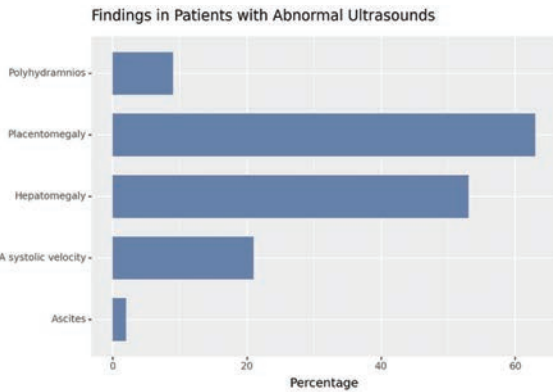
Frequency of ultrasound findings suggestive of congenital syphilis among pregnancies diagnosed after 20 weeks of gestation. MCA, Middle cerebral artery. Elevated MCM systolic velocity defined as MCA systolic velocity (cm/s) >1.5 multiple of the median (MoM) for gestational age.
